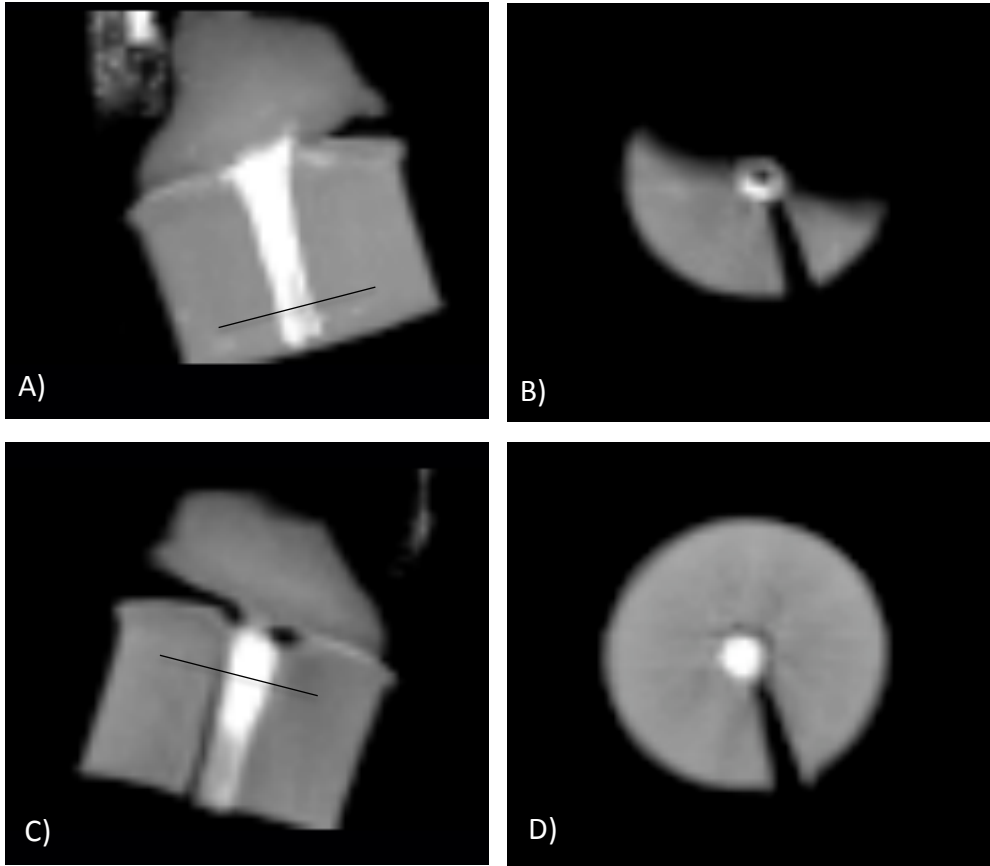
Ex-vivo* CT evaluation of the ameroid constrictor. Images (A) and (B) are sagittal views of the ameroid constrictor. (B) and (D) are cross section images taken at the level of the line in the corresponding sagittal views. The vessel appears open in (B) whereas obstruction of the vessel is apparent in (D)
